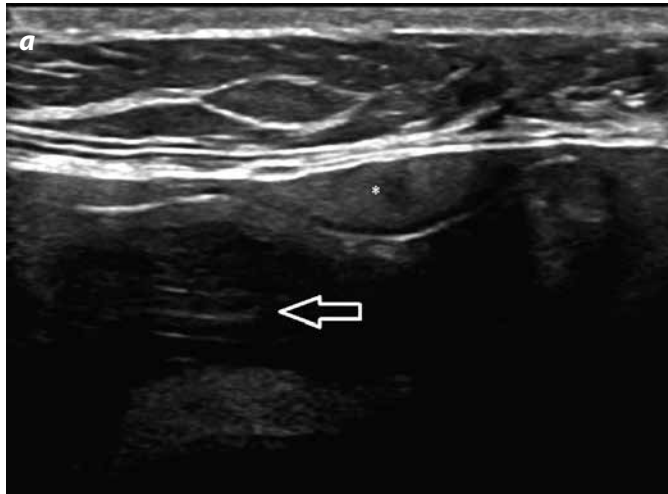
Intracapsular rupture. a) Ultrasound: sign of the "stair" (arrow): multiple discontinuous lines that represent the collapsed foldings of the implant. The sign of the "echogenic folding" (\*): silicone between the foldings. b) Breast MR T2-STIR coronal image with water saturation, the sign of "Linguini".
